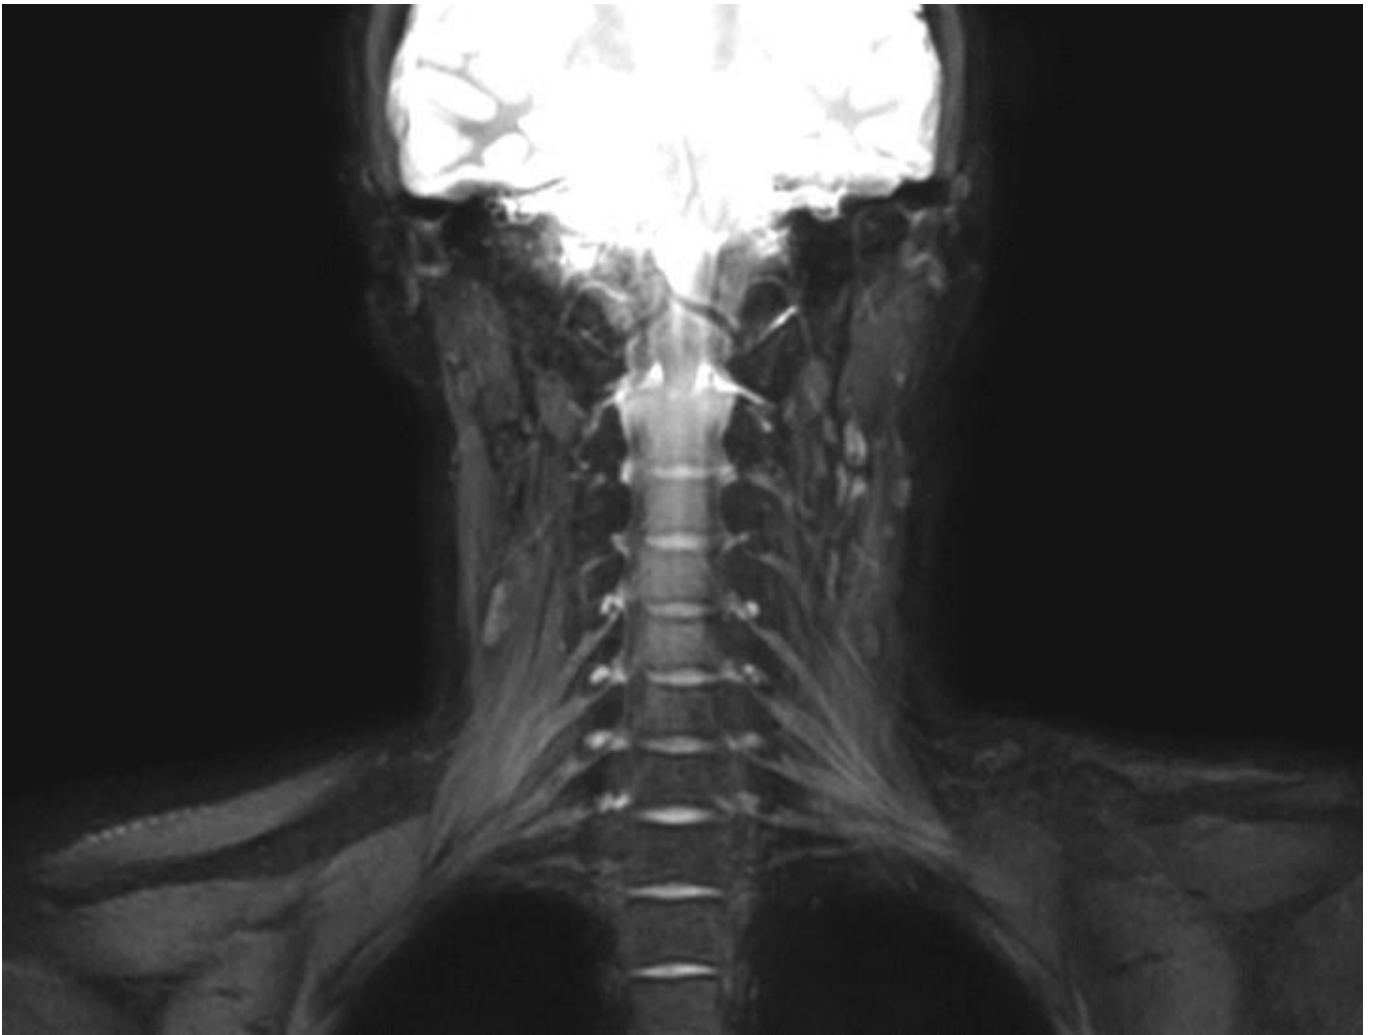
Magnetic resonance image of brachial plexus. There is no significant signal change in the left brachial plexus. Rather, at the trunk level of the right brachial plexus, it appeared loose with a concave shape at the top, while the left side appeared tight, with the top nearly straight or convex.
